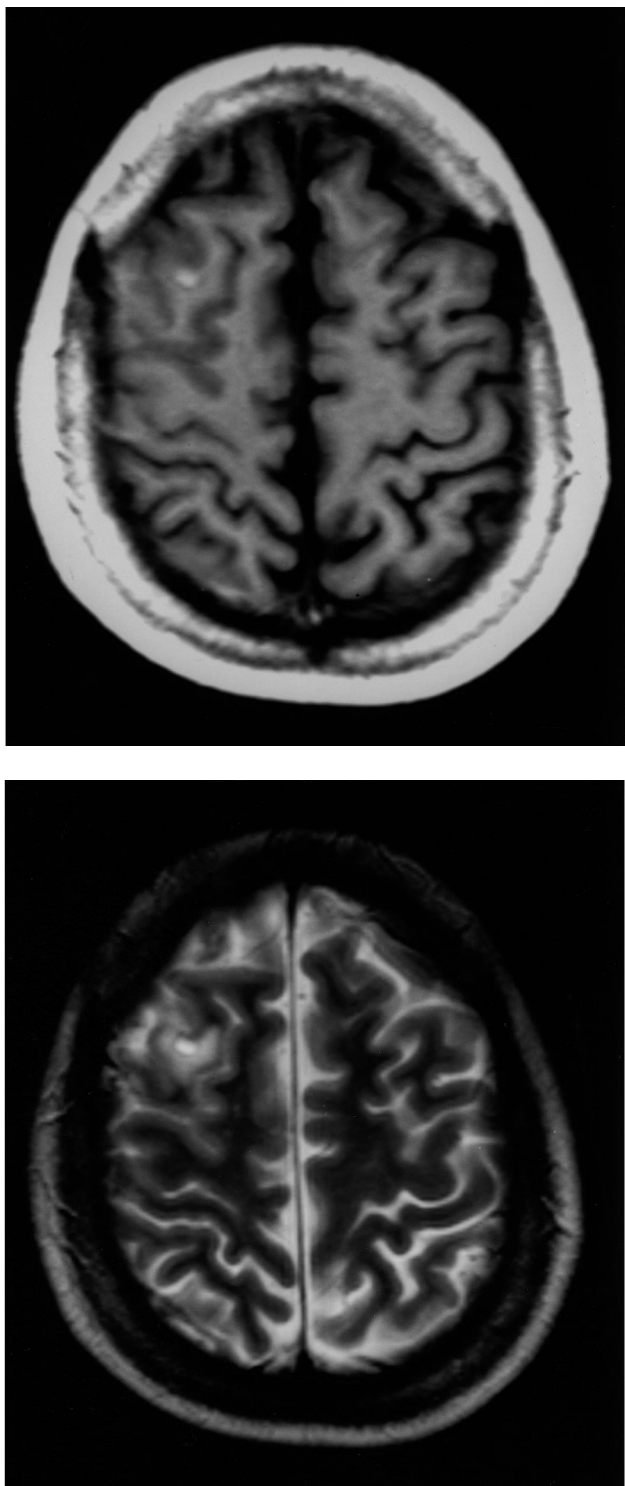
Axial T1- (a) and T2-weighted (b) magnetic resonance images show an area of high signal intensity in the right frontal lobe, indicating a hemorrhagic venous infarct.
